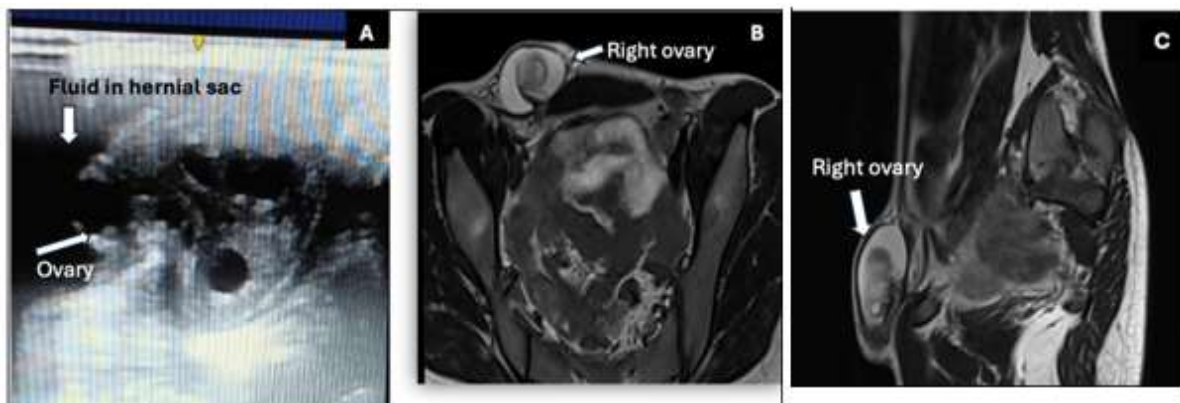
(a) Ultrasound image showing right ovary in hernial sac with fluid around it. (b) MRI image (trans axial section) showing ovary in inguinal canal. (c) MRI image (sagittal section) showing ovary in inguinal canal.
